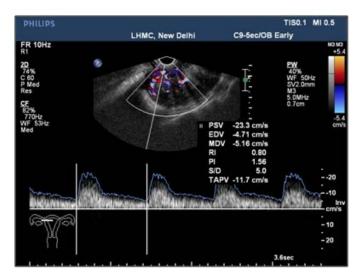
Doppler ultrasound showing adenomyosis having central vascularity. RI = 0.80 and PI = 1.56.
